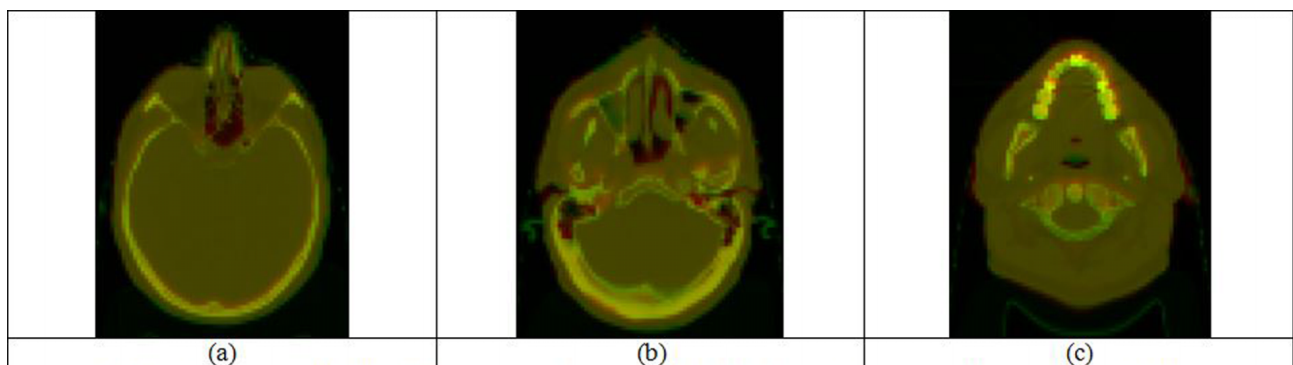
Model generated kVCT (red) images overlaid on weekly kVCT (green) images at three axial levels. Yellow areas show good agreement between the model generated images and the weekly CT images. Areas tinted more green or red show a disagreement where one image had a higher intensity.
